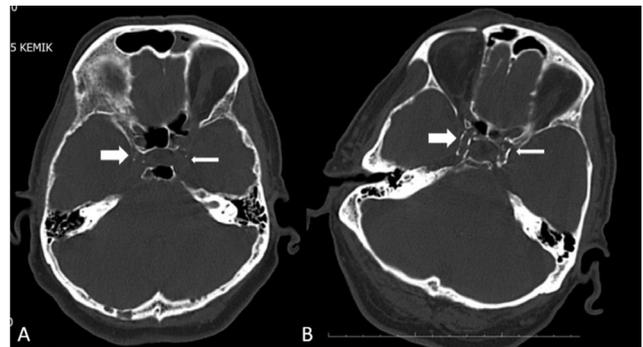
Non-contrast axial CT images with bone window setting showed A); grade 1: point calcification cavernous segment of ICA (thick arrow), cavernous sinus (thin arrow), B); grade 4: double tract calcification cavernous segment of ICA (thick arrow), cavernous sinus (thin arrow)
